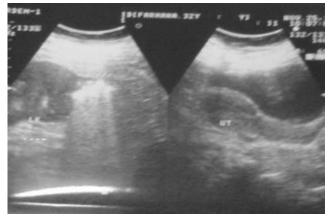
Ultrasonogram showing echogenic components with dirty shadows within parenchyma, calyces and pelvis of left kidney suggesting left sided emphysematous pyelonephritis
